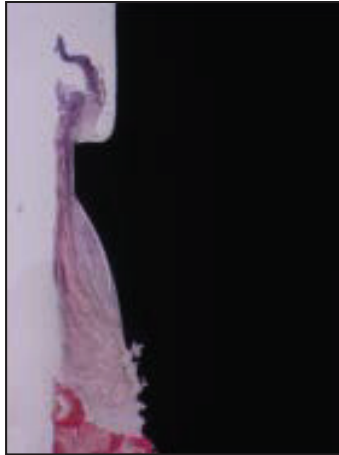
(left) The SE was composed of parakeratinized epithelial cells and had a length of about 1.2 to 1.3 mm. The JE had a length of about 1.0 to 1.5 mm. CT attachment was 1.2 mm (toluidine blue–basic fuchsin; original magnification $\times 50$).
